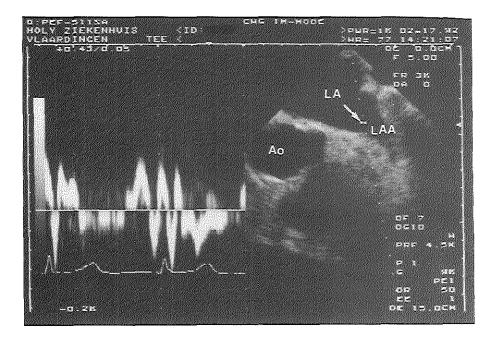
Pulsed Doppler flow measurements in left atrial appendage during transesophageal echocardio-graphy. The sample volume is located at the entrance of the atrial appendage (arrow). Ao= aorta; LA= left atrium. LAA= left atrial appendage.
